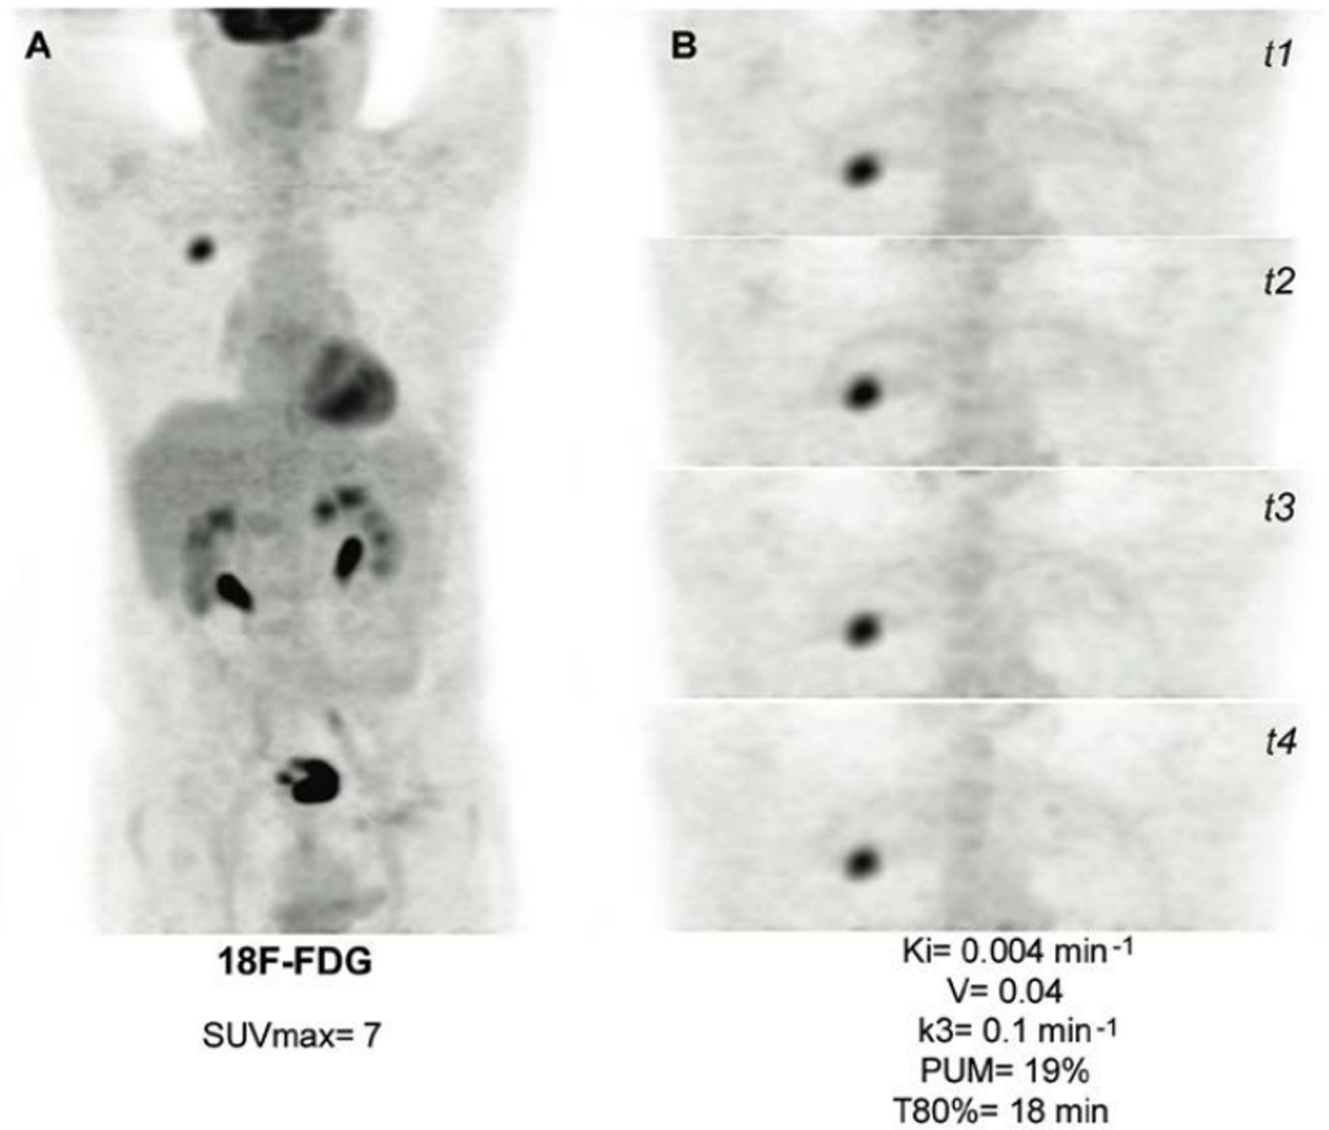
Lung adenocarcinoma. A. ¹⁸F-FDG PET (MIP). B. 4 additional 3D acquisitions centered on the target lesion (¹⁸F-FDG PET MIP).
